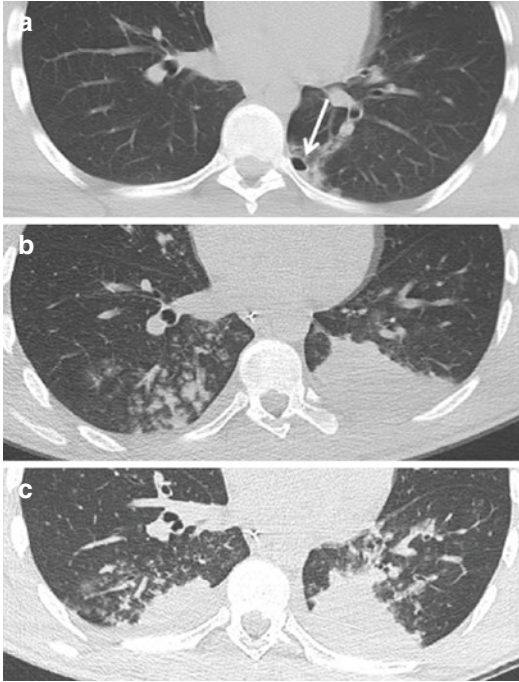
Left lower lobe contusion associated with a small type 3 parenchymal laceration (*arrow*) in a young boy: axial CT-scan immediately after trauma (a). Images in (b, c) show the CT controls after 5 and 10 days: the progressively filling of the small laceration with fluids does not permit its depiction in the successive CT controls
